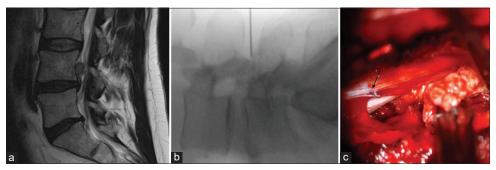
The site of dural puncture by a spinal needle placed in the wrong location during level identification. (a) T2-weighted magnetic resonance imaging showing cranially migrated disc herniation at the level L4-L5. (b) Location of the spinal needle at the level L4-L5, with a relatively deep position between the spinal process. (c) Intraoperative images reveal the single interrupted stitch at the dura (arrow), with depiction of the L5 nerve and underlying disc herniation.
